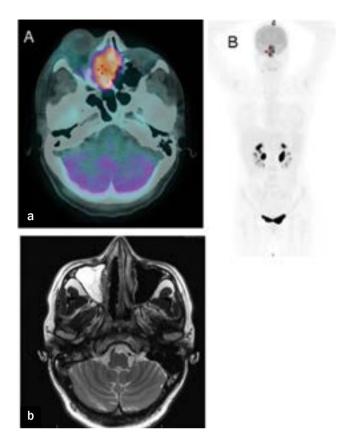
A. Staging PET/CT showed intense uptake in nasalethmoidal mass; a. Fused image; b. MIP image; B. Staging Cervical MRI showed large tumor mass involving right nasal cavity, right ethmoid, sphenoidal and maxillary sinuses
